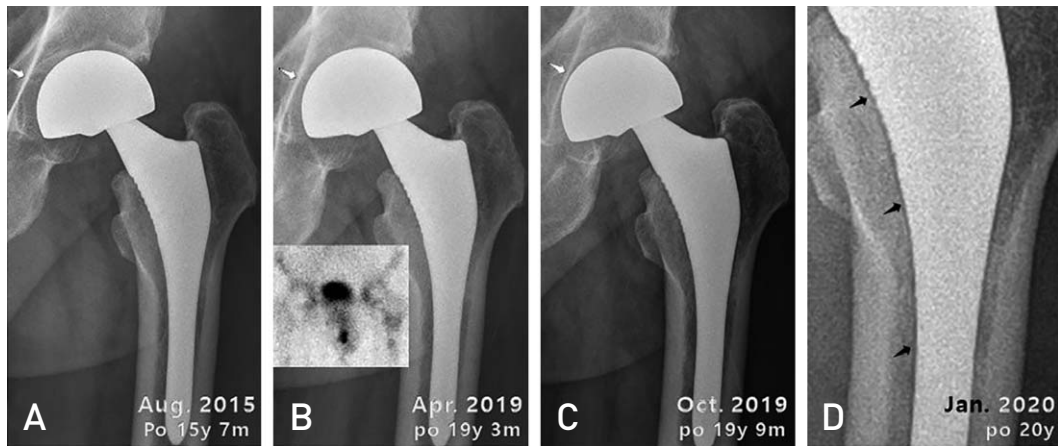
Consecutive postoperative plain radiographs following thigh pain initially reported in January 2019. (A) Plain radiograph of contralateral side total hip arthroplasty. There was no symptom on the left side. (B) Migration of the bipolar cup (white arrows) and increased radioisotope uptake around the proximal half and the tip of the stem (inset) noticed in April 2019. (C) Rapid progression of the cup migration apparent in October 2019. (D) A fine radiolucent line along the medial margin of the stem (black arrows) detected in January 2020.
